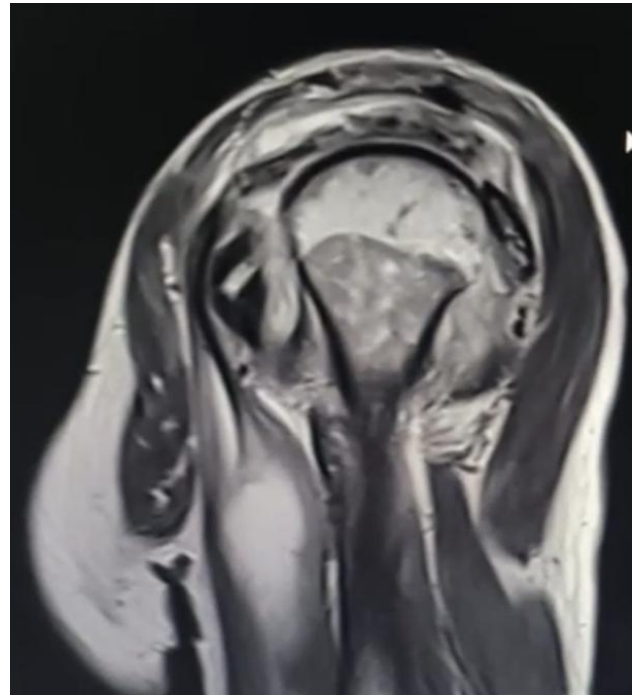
MRI of the right shoulder demonstrating glenohumeral joint effusion with synovial thickening and subchondral marrow signal abnormality of the humeral head, in keeping with septic arthritis.
